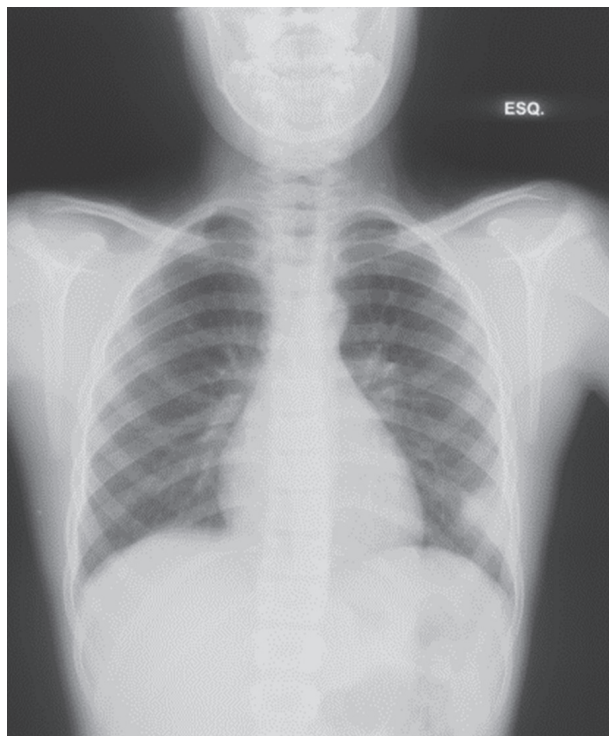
Chest radiography showing the hypotransparency of the left pulmonary inferior lobe (circle).
